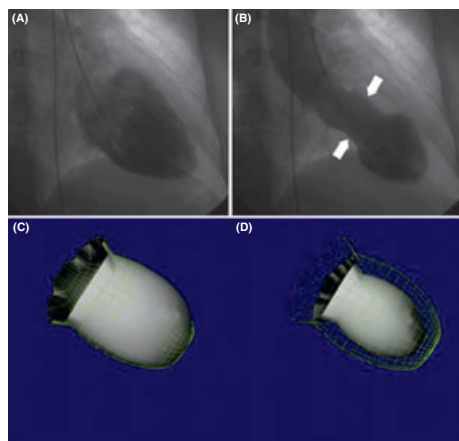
Left ventriculography images. (A, B) Initial images revealed mid-apical akinesia and basal hyperkinesia (arrow) in the conventional ventriculography obtained after the coronary angiogram. (C, D) Control scintigraphic ventriculography showed that the mid-apical akinesia returned to normal 1 day later.
